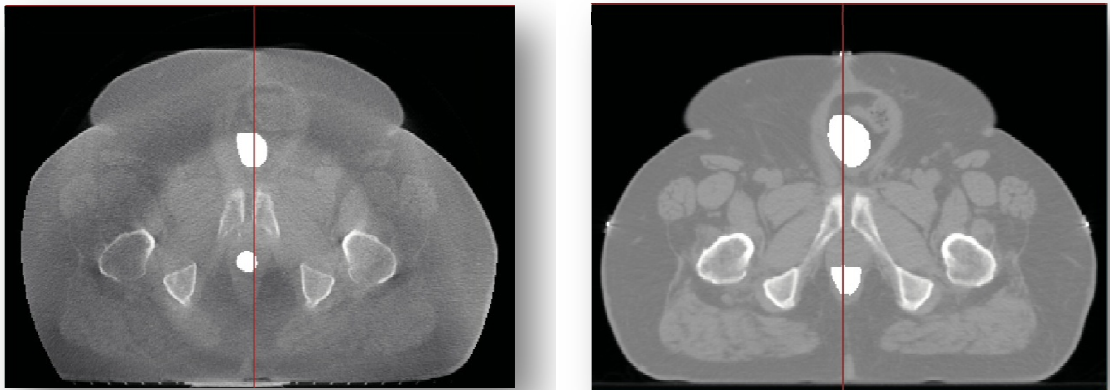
Pre-processed CBCT (left) and planning CT (right) images.
